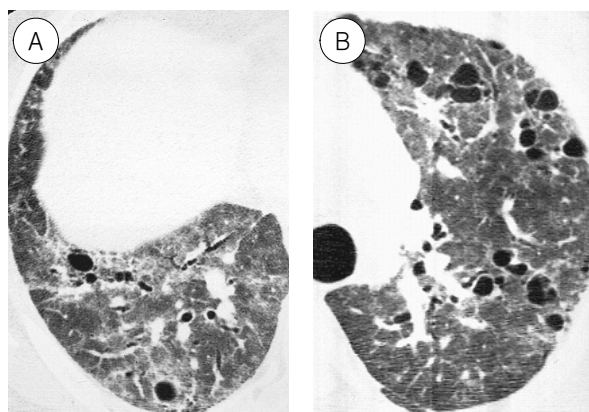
Lymphocytic interstitial pneumonia in a 28-year-old woman. (A) HRCT scan at level of liver dome shows patchy distribution of ground glass opacity, centrilobular nodules and reticular opacities in right lung. (B) At level of aortic arch HRCT scan shows perivascular cysts and subpleural nodules in left lung.
